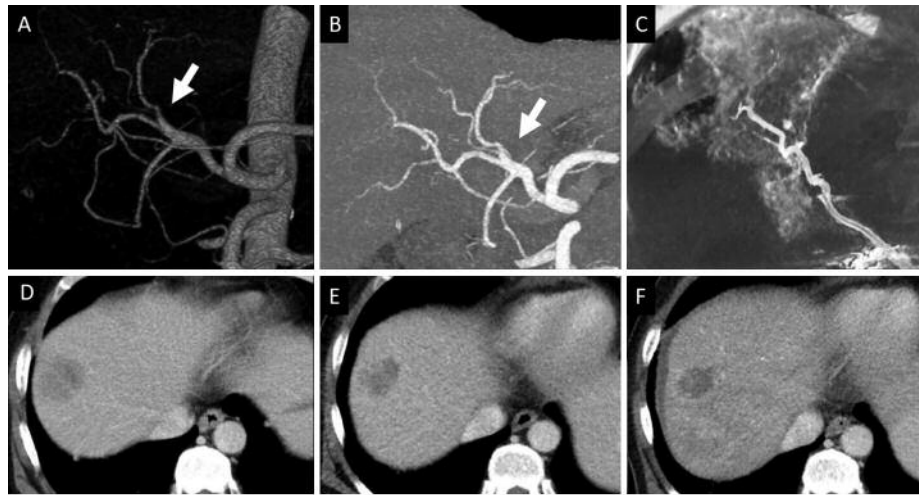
Computed tomography angiography (CTA) of the liver showing the intrahepatic segmentation of the hepatic artery. A trifurcation of the hepatic artery (arrow) is visible. The supplementary artery supplies the gall bladder and part of the metastasis. A: CTA, volume-rendered 3D reconstruction. B: CTA, maximum intensity projection of hepatic arteries. C: Catheter-based perfusion image from cone-beam CT. D: Axial CT image of liver metastasis before transarterial radio-embolisation (TARE). E: Axial CT image 6 weeks after TARE. F: Axial CT image 6 months after TARE, with visible size reduction and decrease in density representing necrosis.
